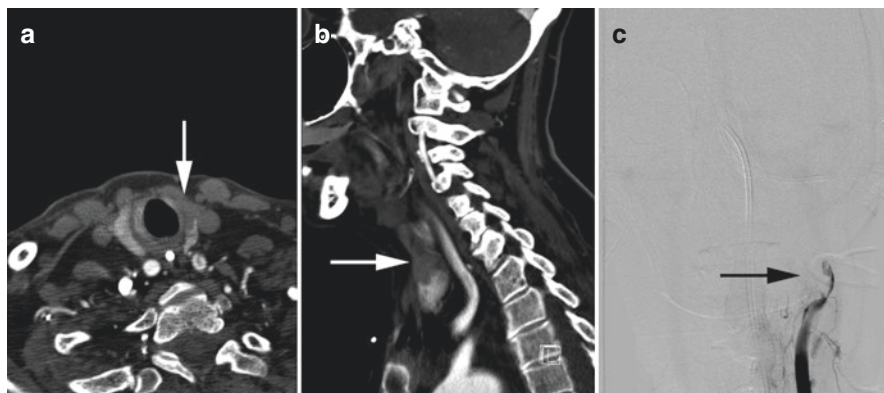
Superior thyroid infarction. Patient with acute left hemispheric infarction related to left carotid occlusion involving both the ECA and ICA. Thrombus extended into the left superior thyroid artery resulting in superior thyroid lobe infarction (white arrows) on axial (a) and sagittal CTA (b). DSA with delayed imaging confirmed left ICA and ECA occlusion (c, black arrow)
